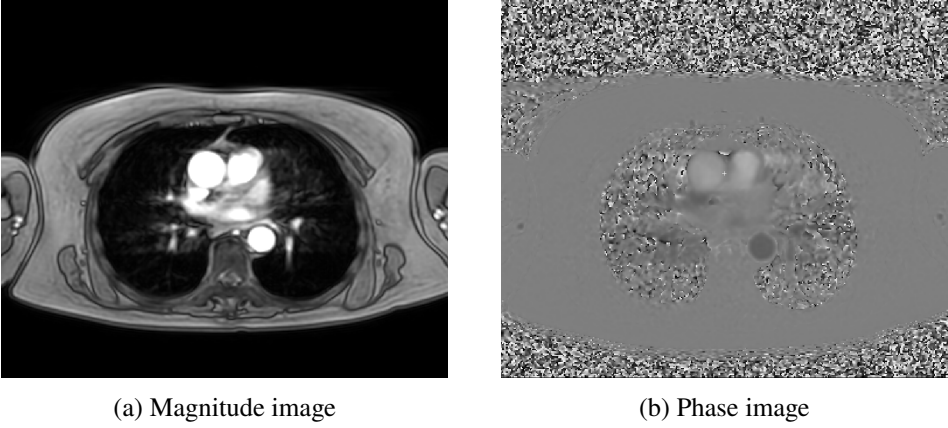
2D PC MRI magnitude and phase images.
